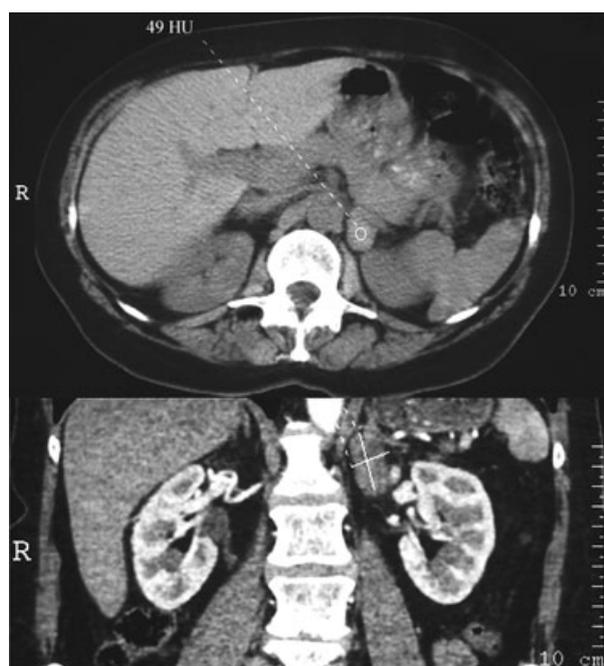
Incidental finding on prospective live-donor CT angiography. Top: precontrast axial images showed a 24-mm lesion in the region of the left adrenal gland (circle). Bottom: no contrast enhancement with axial dimension of 28 mm. Left nephrectomy was performed and revealed a mass separate from the adrenal; urothelium was demonstrated on frozen section and donor nephrectomy proceeded uneventfully.
